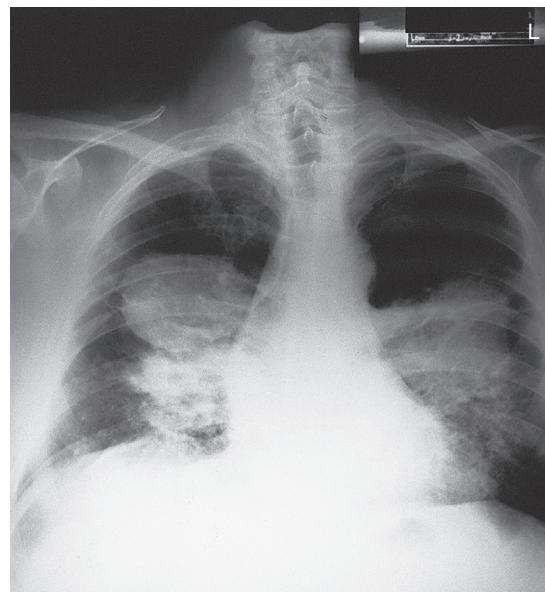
Chest radiograph demonstrating large perihilar nodules. Thoracotomy revealed heavy anthracotic pigmentation, with the two largest nodules containing black fluid, consistent with anthracosis. (From American College of Radiology, Reston, Virginia.)
